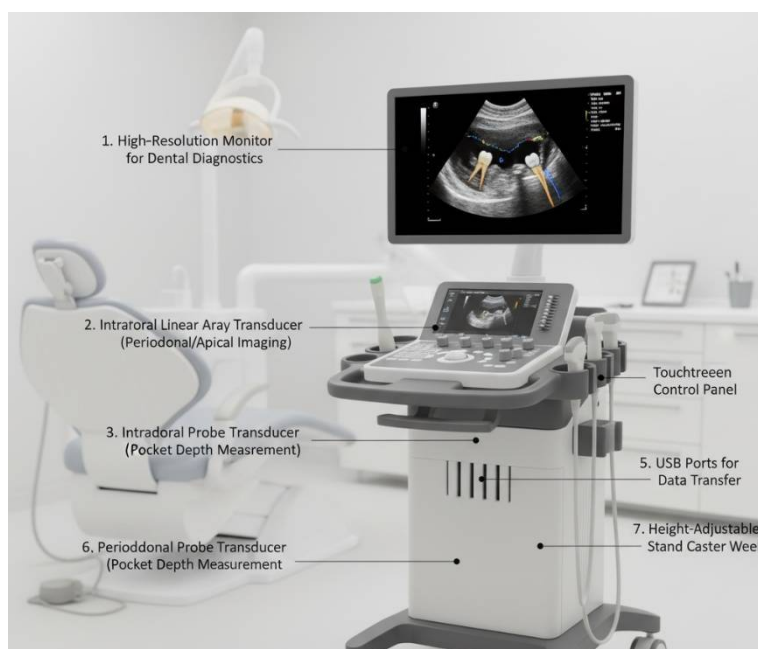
Ultrasound Machine and Parts
